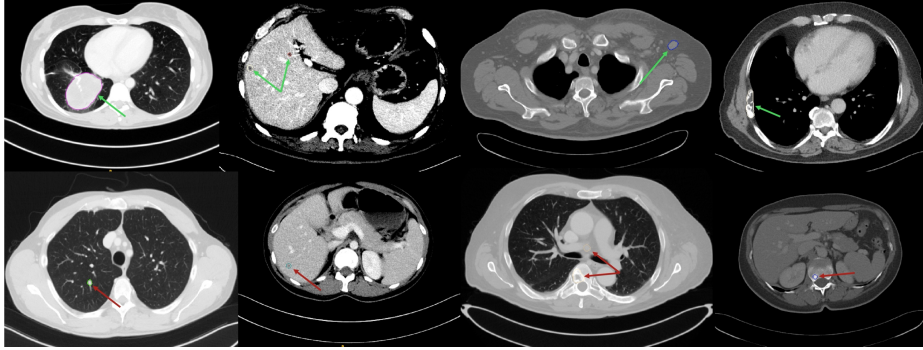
Example outputs generated by our multi-organ framework for universal lesion detection and segmentation in CAP CT scans. The first row shows to true positive lesions in the lung, liver, skin and bone (left to right). The second row highlights examples of false positive detections.
